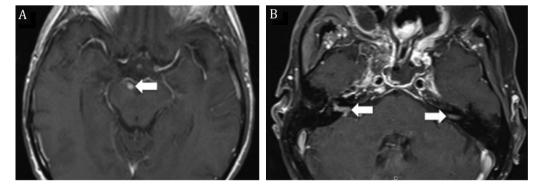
T-1 weighted gadolinium-enhanced cerebral MRI, axial slices. A. Right pre-mesencephalic uptake as of the 3rd cranial nerve (⇔). B. Bilateral uptake in acoustic-facial bundles (⇔ ⇔).
